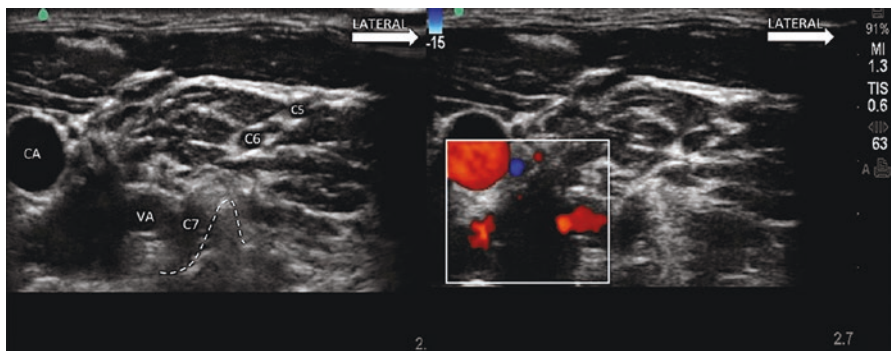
Sonography at C7. VA, vertebral artery; CA, carotid artery. (Reprinted with permission from Philip Peng Educational Series)
